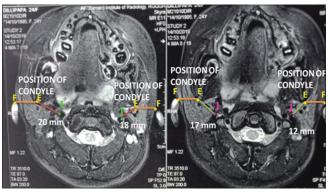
Axial section of MRI showing position of condyle (orange line-a horizontal line EF drawn from a point just in front of the ear (Point F), Distance EI-deep red line, Distance EJ – green line. MRI: Magnetic resonance imaging
